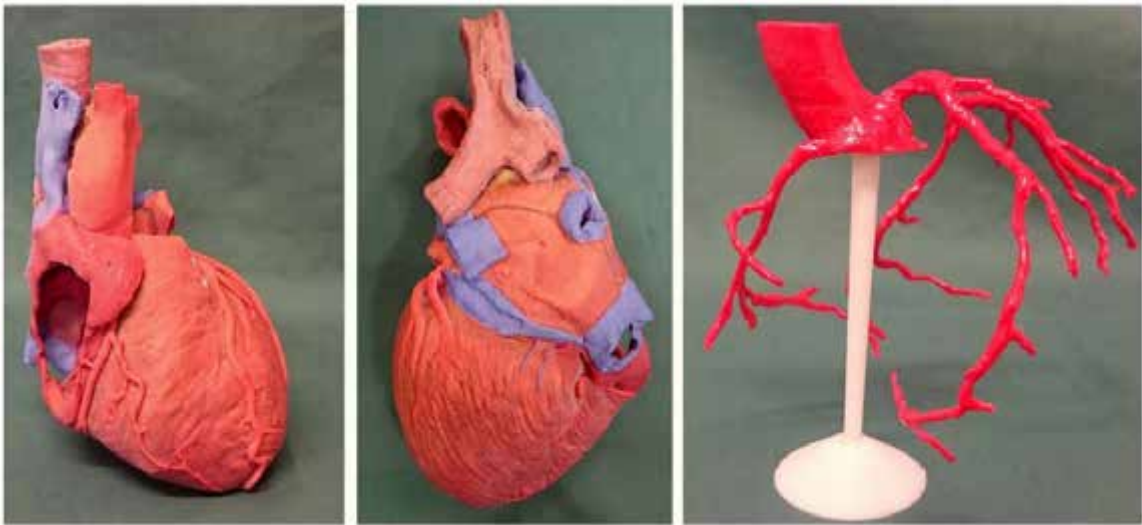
Cardiovascular models from surface scanning and CT scan data (Lim et al, 2014)
